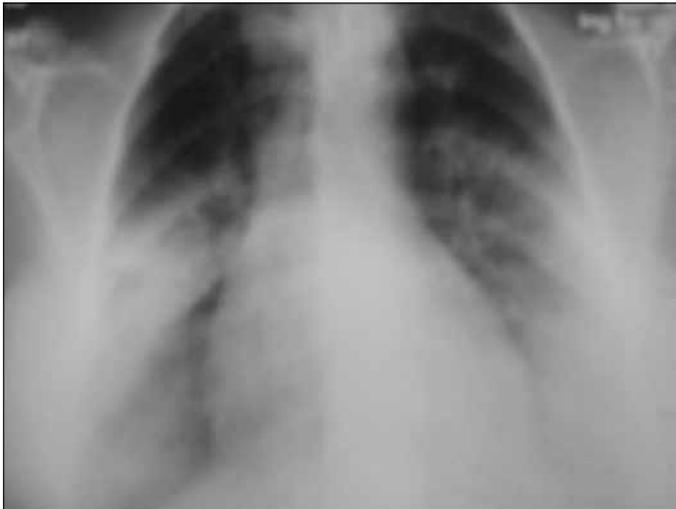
Chest x-ray depicting cardiomegaly and bilateral infiltrations predominantly in the middle and lower zones of the lungs
